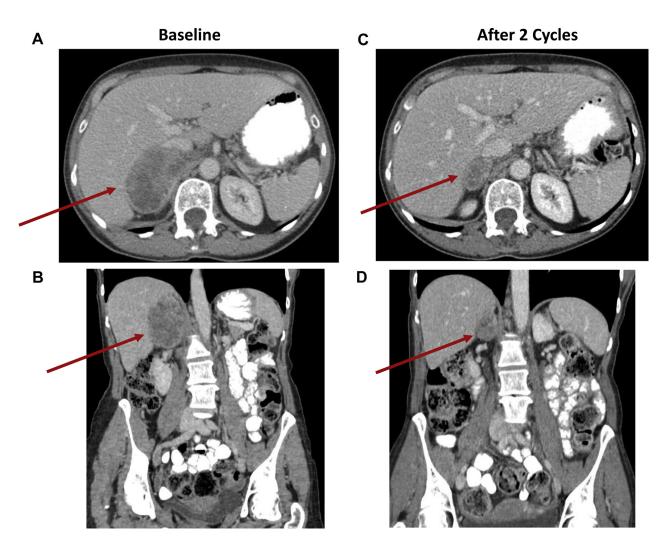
(*A*, *B*) Baseline axial and coronal computed tomography images from a patient with *RET*-positive NSCLC before study entry. A large right adrenal metastasis is highlighted by red arrows. (*C*, *D*) Repeat axial and coronal computed tomography images after two cycles of ponatinib reveal a marked interval reduction in the size of the right adrenal metastasis.
